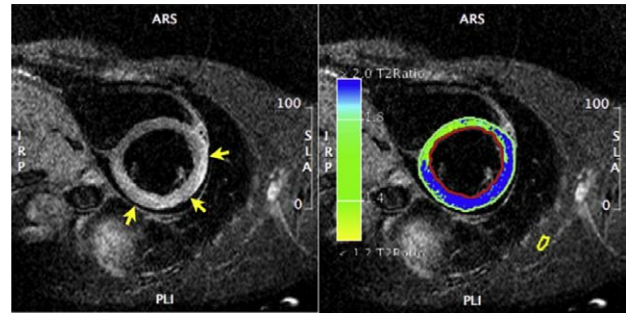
Myocardial edema in a patient with clinically acute myocarditis. Left, Water-sensitive cardiovascular magnetic resonance image in a midventricular short-axis view as acquired with the body coil (note the homogeneous signal distribution in the field of view). There is increased signal intensity in the anterior anterolateral, lateral, inferolateral, and inferior segments, which seems more pronounced in the subepicardial layer. Right, signal intensity ratio map showing pixels with a ratio of ≥ 2.0 (compared with the region of interest in the skeletal muscle marked by the yellow contour) as blue. The normal signal intensity in the septal segments (≈ 1.6) indicates absence of a low-signal intensity artifact. Note that there is mild pericardial effusion that seems black because of the flow suppression pulse of this sequence.
